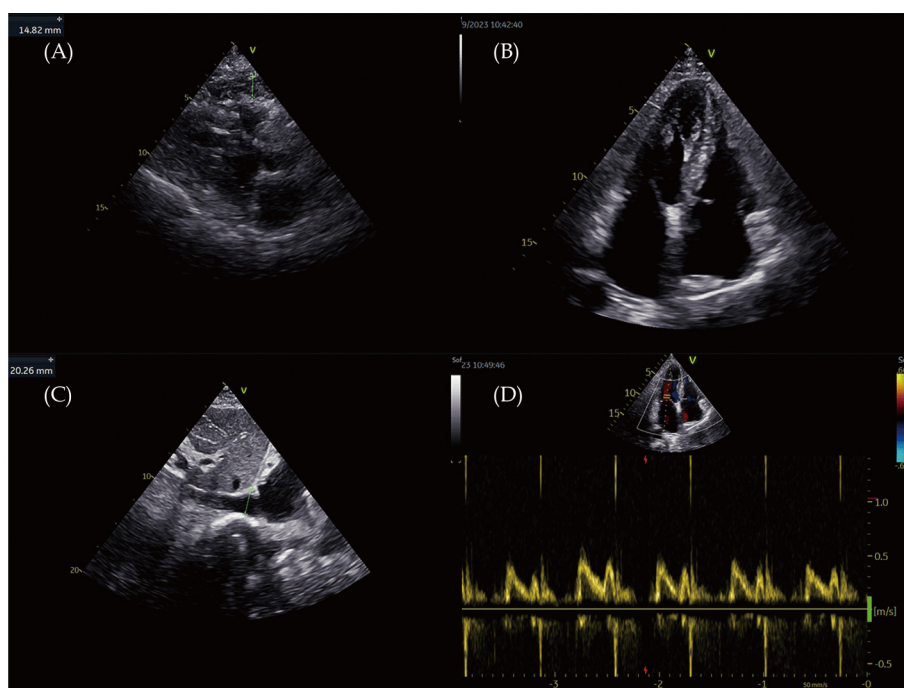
Echocardiography images when the patient was admitted. (A): Transthoracic echocardiography showed pericardial thickening; (B): transthoracic echocardiography apical four-chamber view demonstrated constriction of the pericardium (C) the inferior vena cava was not widened (D) mitral flow changed with respiration.
